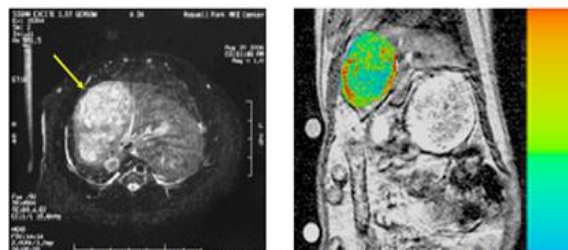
(A) Axial MRI image of a HCC (arrow) in a woodchuck. (B) Sagittal MRI image of a HCC in a woodchuck with Ktrans overlay
